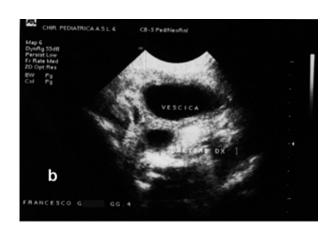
Modifications in hydronephrosis (a,c,e) and ureteral dilation (b,d,f) on ultrasound scans in patients with resolution. At presentation, (a) severe dilation of renal pelvis visible, associated with (b) right ureter having cross-section diameter greater than 10 mm. After 6 months of stenting, (c) hydronephrosis had improved and (d) ureter completely decompressed. Stent visible within bladder (gray arrow). Finally, 3 months after stent removal, (e) only mild residual hydronephrosis persisted, with (f) recurrent ureteral dilation no longer evident.
